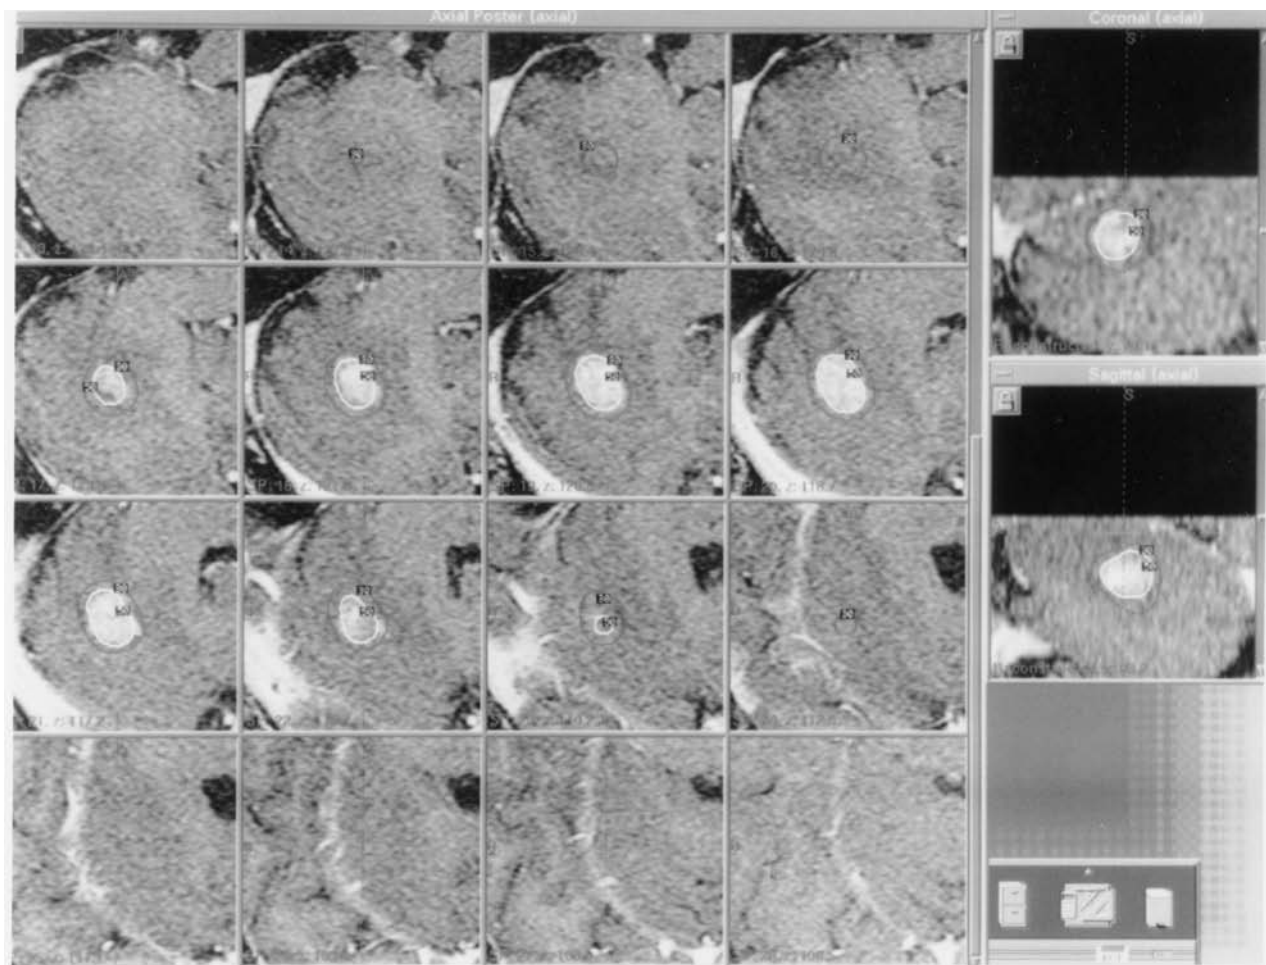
Radiosurgical dose plan for the treatment of a small cell lung carcinoma metastasis in the right cerebellum. Axial, coronal, and sagittal MR images are shown. The respective isodose curves are denoted by the numbers on the dose plan.
